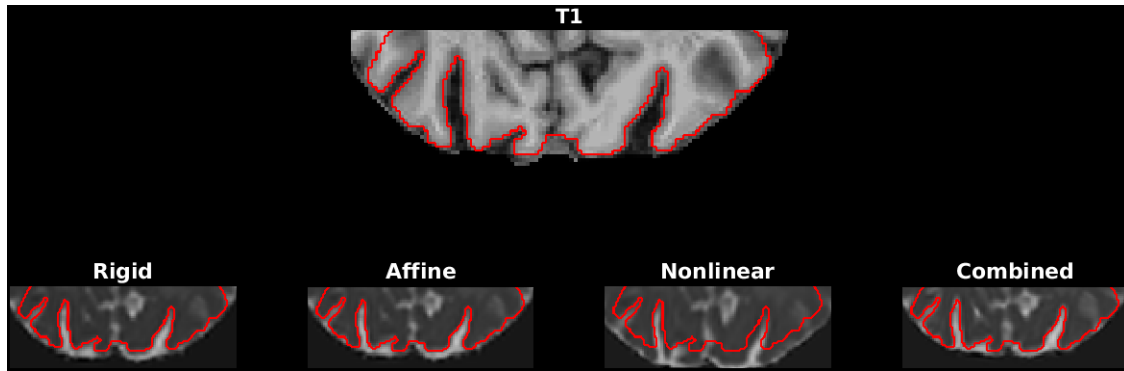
The outlining of the T1-weighted image in the posterior part of the brain, together with the four registration approaches (driven by b_0) used where the outlining is applied on the MD-image. The outlining of the nonlinear is not located around the cortex as it should be, implying a low registration accuracy. The Jaccard indices for the registrations are the following from left to right: 0.9822, 0.9767, 0.9809, 0.9586.
